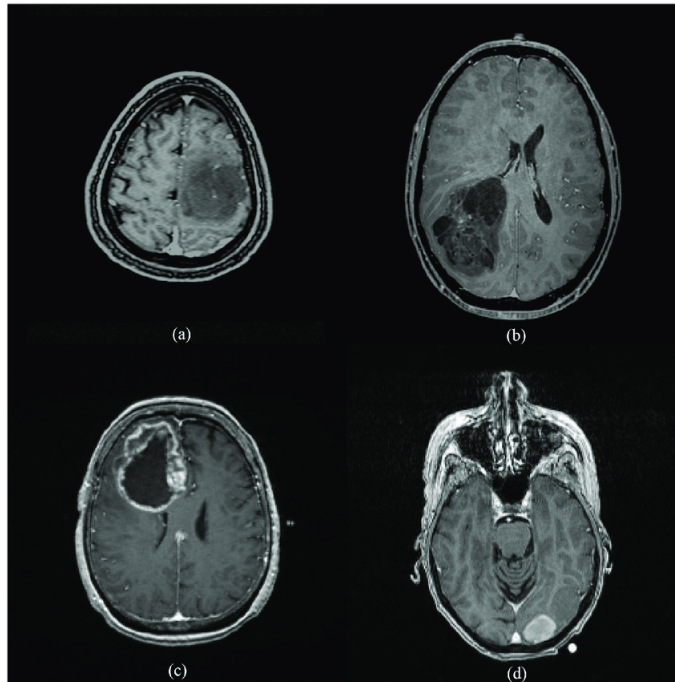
Examples of glioma tumors as captured by magnetic resonance imaging. *Upper row: Low-grade gliomas. Lower row: High-grade glioblastomas.* Figure taken from Hsieh *et al.* [132].
